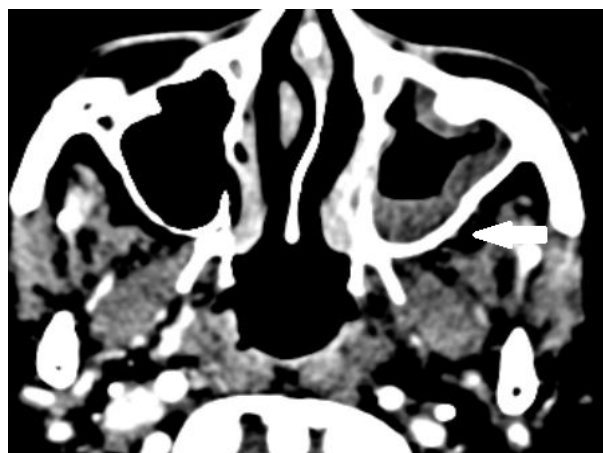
Left maxillary fungal sinusitis- Unenhanced axial computed tomography image showing mucosal thickening in left maxillary sinus (arrow) which was proved on KoH study to be mucormycosis.
